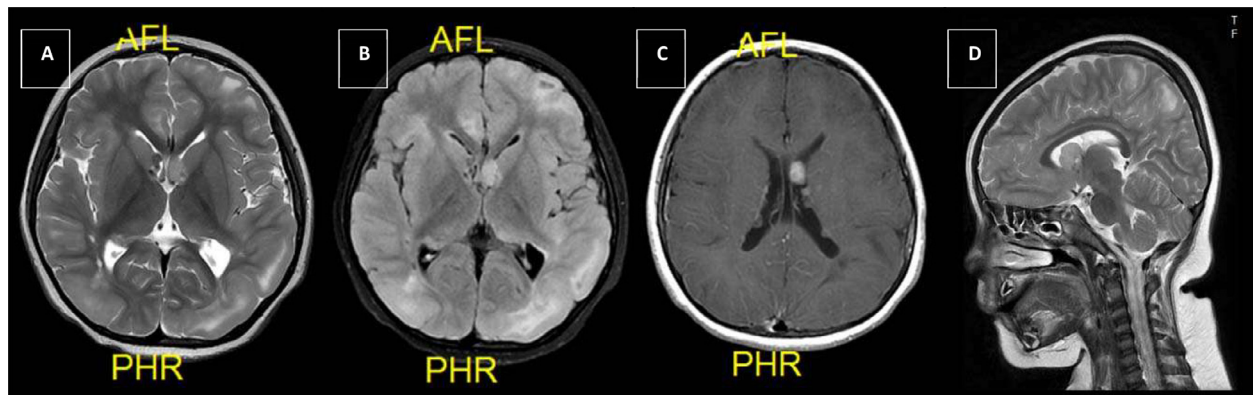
Solid nodule revealed in the brain MRI with intermediate intensity at T2 (A) and hyperintense at T2Flair (B). It was homogeneously enhanced, measuring about 1.5 x 0.9 x 1.7 cm, originating from the subependymal line of the anterior horn of the left lateral ventricle and enhanced at the Gd-DTPA (C). In the sagittal view, the nodule was visibly seen at the third ventricle and identified near the foramen of Monro, which is indicative of SEGA.
